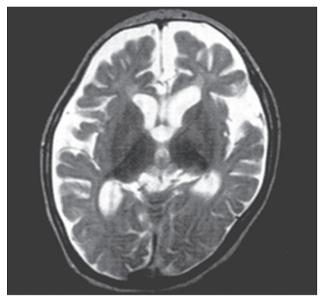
Brain MRI (T2 weighted) at three years and two months of age, revealing moderate brain atrophy with diffuse T2 high intensity in the white matter.
